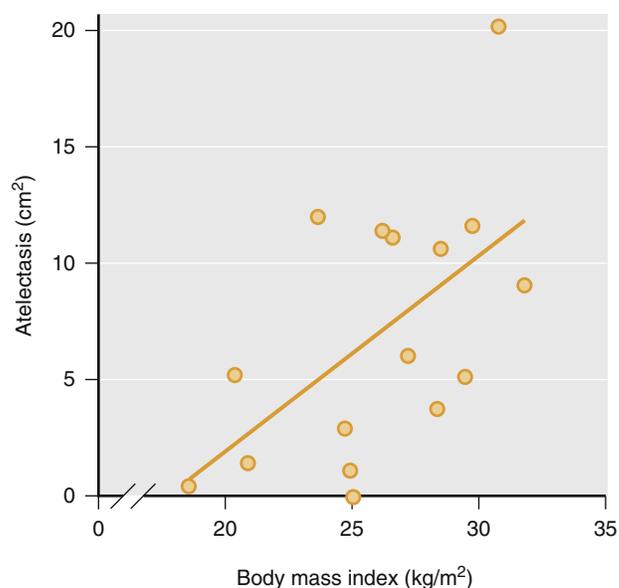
Relationship between body mass index (BMI) and extent of atelectasis during general anesthesia. As BMI increases, so does the extent of atelectasis (although there is considerable variability). (From Rothen HU et al: *Re-expansion of atelectasis during general anaesthesia: a computed tomography study*, Br J Anaesth 71:788-795, 1993.)
